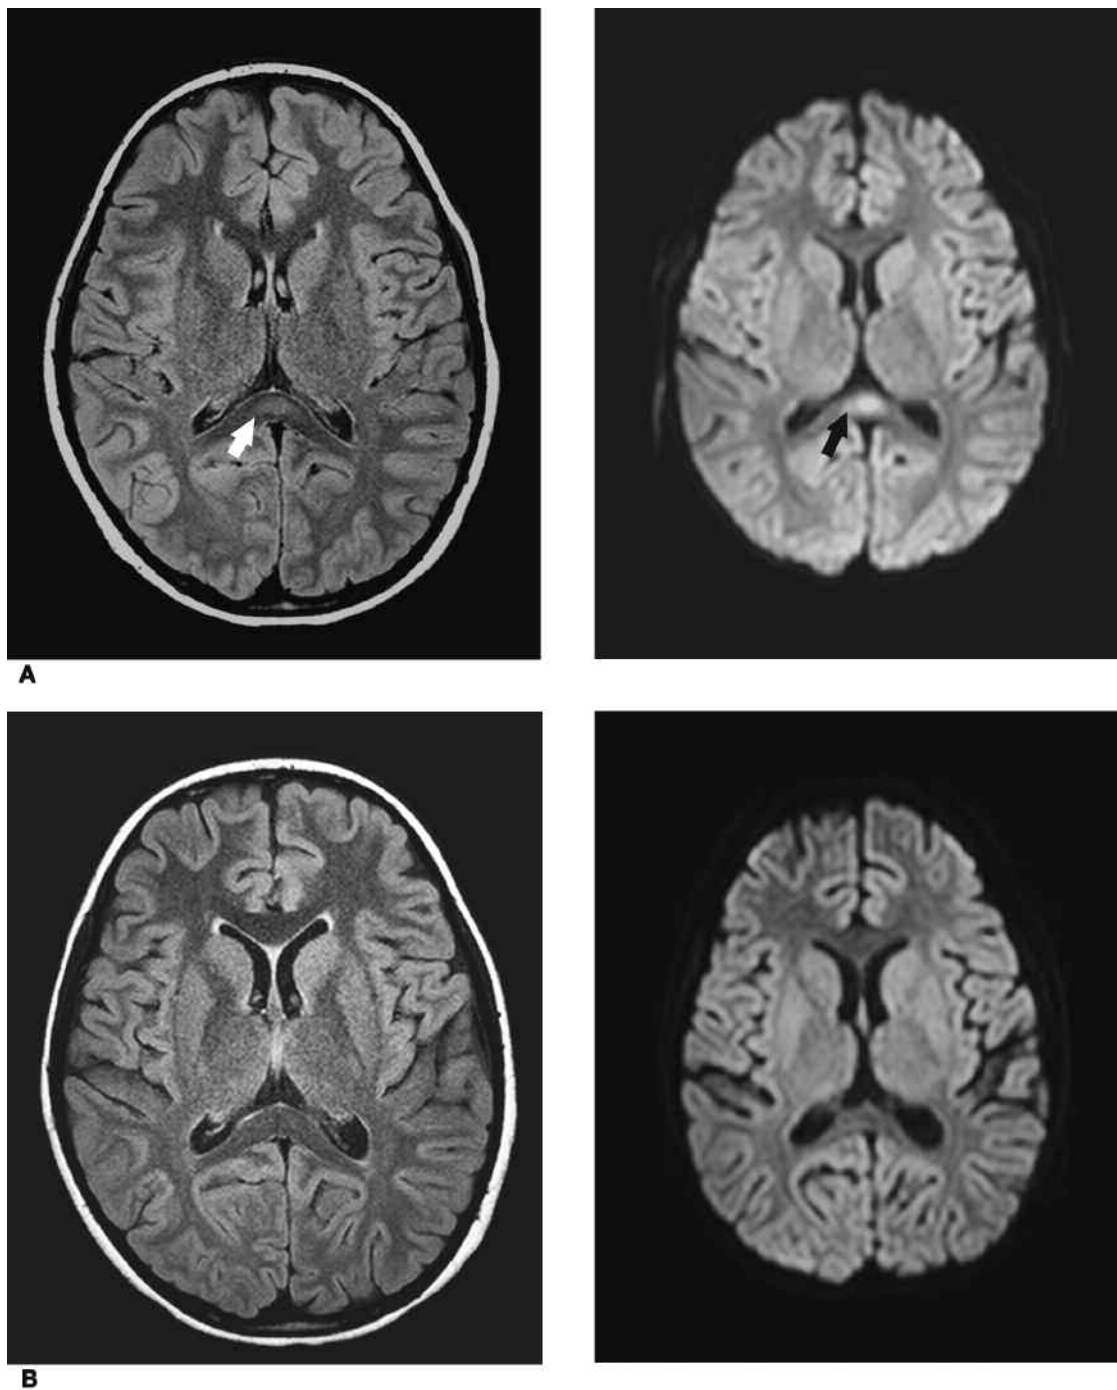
A. Initial magnetic resonance imaging (MRI) examination showed abnormal T2 and FLAIR signal with restricted diffusion in the posterior aspect of the corpus callosum and no other diffusion-restricted lesions. B. Followup MRI 2 weeks later was normal.
